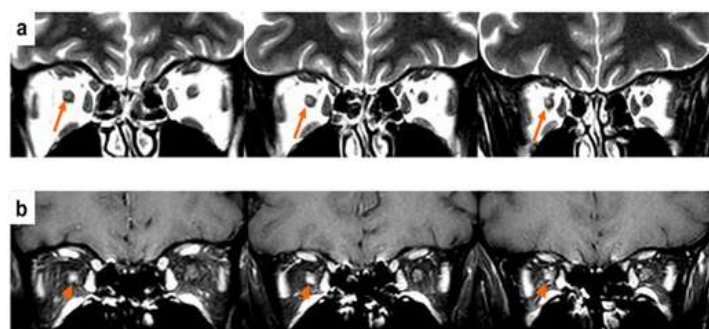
Optic nerve lesions in multiple sclerosis. The posterior endoribital part of the right optic nerve is enlarged and exhibits hyperintensity (orange arrows) on the coronal fat-suppressed T2-weighted sequence. On the post-contrast T1-weighted sequence, there is a focal gadolinium enhancement (orange arrowhead).
